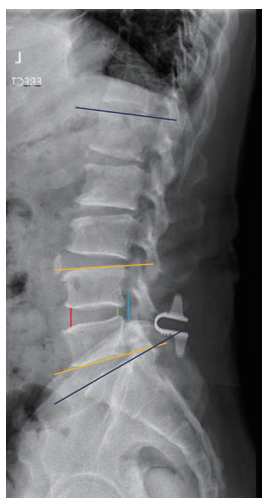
Lumbar spine lateral radiograph, taken while standing erect, of a patient who underwent decompression surgery and interlaminar device insertion at L4/5 measuring overall lumbar lordosis (dark blue line), sagittal angle (orange line), anterior disc height (red line), posterior disc height (green line) and foraminal height (blue line).
